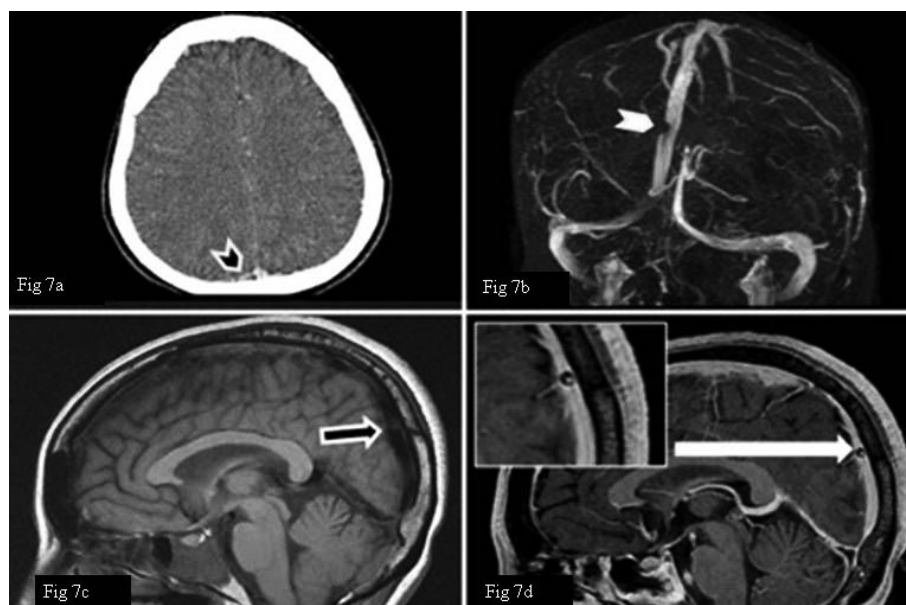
CTV in axial plane showed a filling defect within the superior sagittal sinus (SSS) (black arrowhead). Figure 7b. 2D-TOF MRV projection showed a similar nodular filling defect indenting the sidewall (white arrowhead). Figure 7c. On sagittal T1-weighted image, there was an isoechoic signal intensity seen within the SSS (black arrow) mimicking a thrombus. Figure 7d. Contrast-enhanced MPRAGE sagittal image confirmed the filling defect with associated internal vein (white arrow) (enlarged inset image). These findings are consistent with pacchonian arachnoid granulation.
